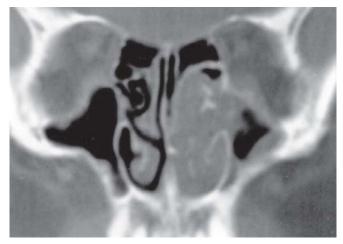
CT scan coronal section showing soft tissue mass in right ethmoids and nasal cavity (inverted papilloma)
